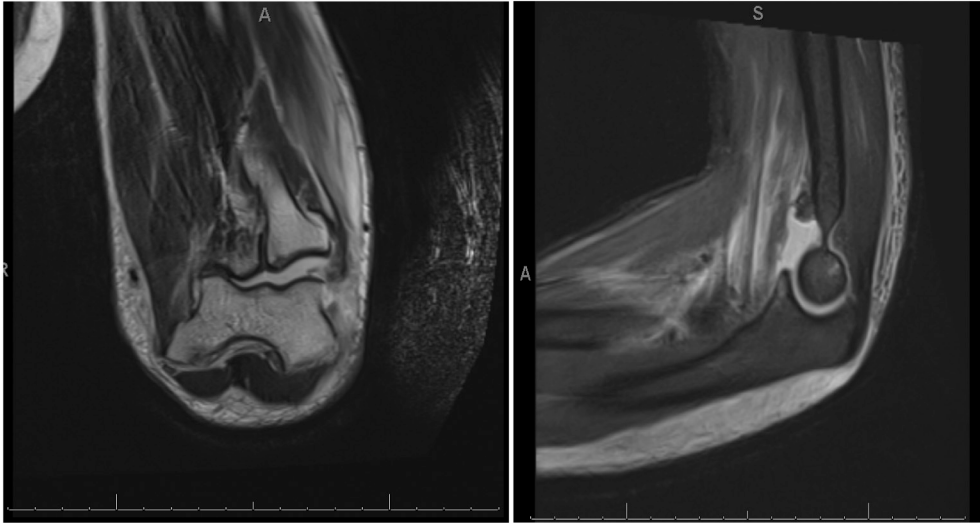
Magnetic resonance imaging with contrast.
